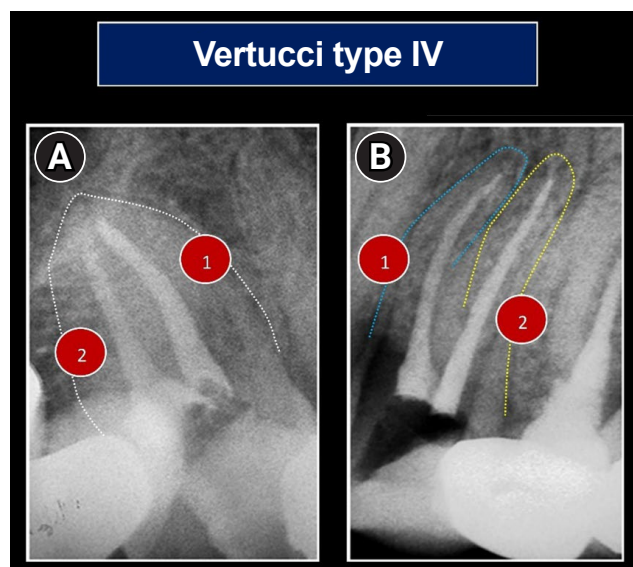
Periapical radiographs of a single-rooted (A) and double-rooted (B) maxillary premolar which are classified the same using the Vertucci classification, that is, type IV (two separate canals). Reproduced and modified from Ahmed *et al.* [18], according to the Creative Commons License.
